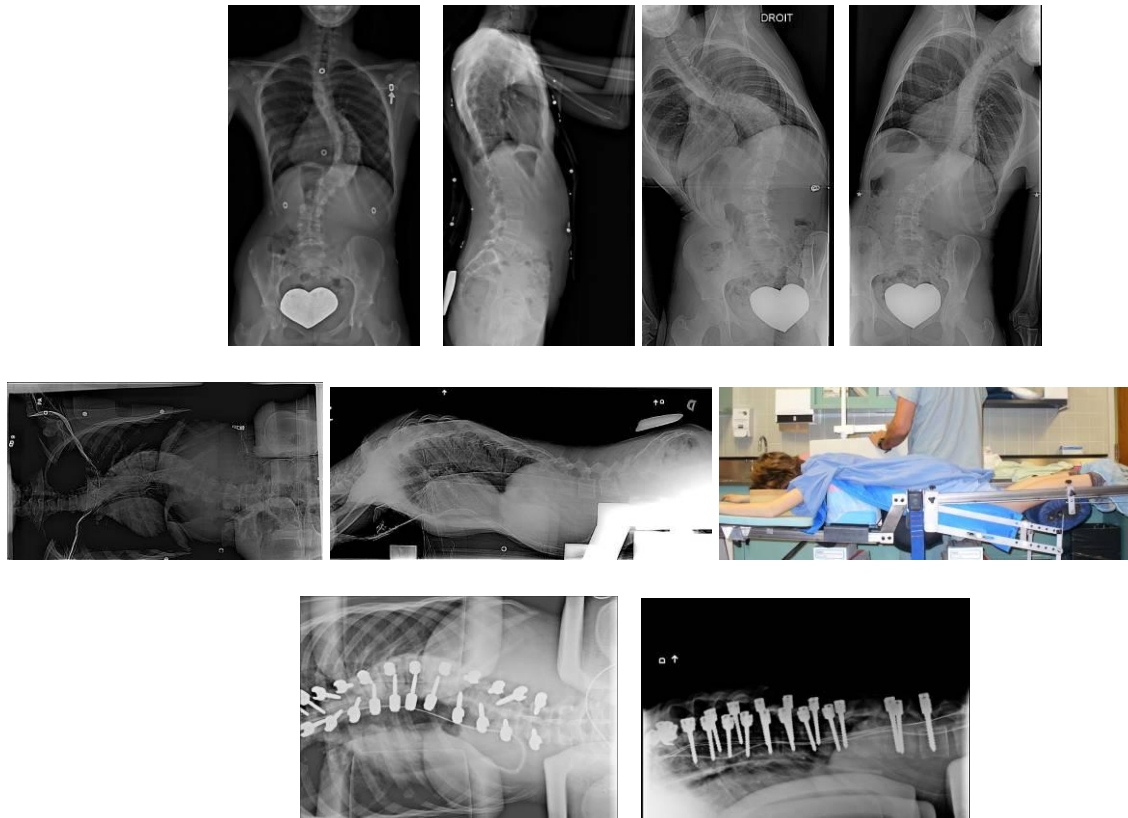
(A1F1): Representative radiographs of patient #1 from left to right, top row: PA standing, lateral standing, left and right standing lateral bending; middle row: PA and lateral on MFPF with picture of experimental setup; and bottom row: PA and lateral on Relton-Hall frame
